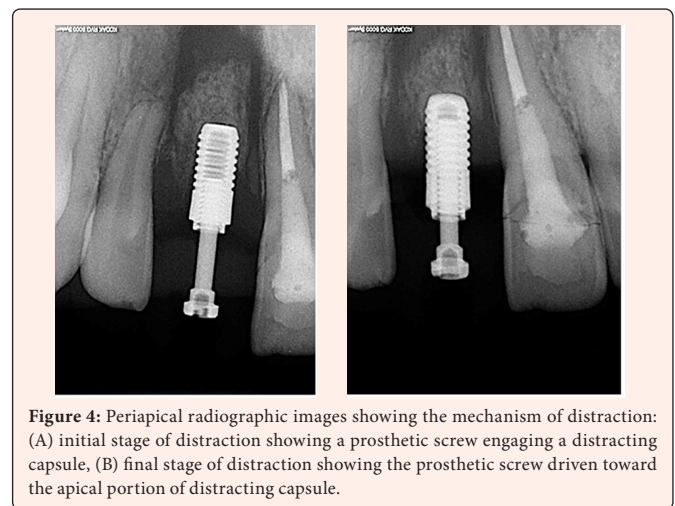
Periapical radiographic images showing the mechanism of distraction: (A) initial stage of distraction showing a prosthetic screw engaging a distracting capsule, (B) final stage of distraction showing the prosthetic screw driven toward the apical portion of distracting capsule.
